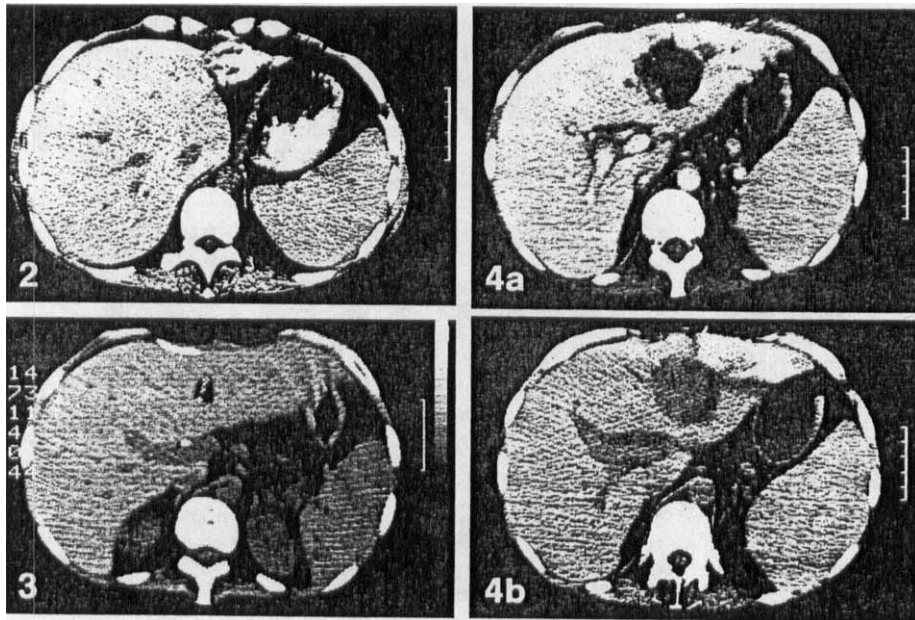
CT scan with intravenous contrast demonstrating the liver transplant 4 months after a left hemihepatectomy without any recurrence of malignancy
